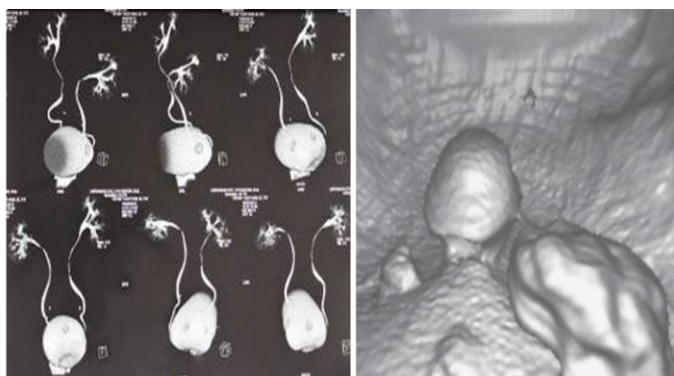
Visualization of multiple tumors of the bladder: a) CT virtual urogram b) virtual cystoscopy.
